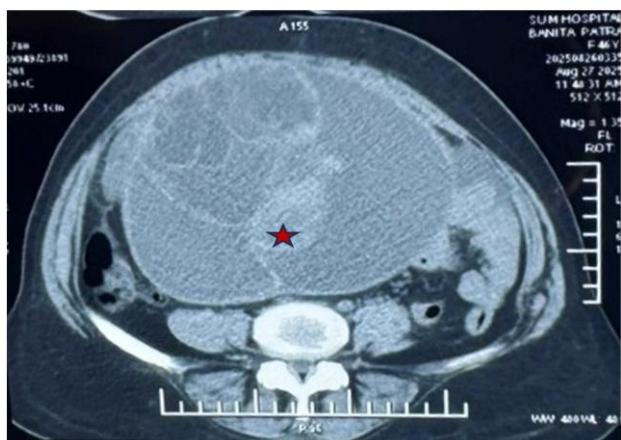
Contrast-enhanced CT showing multiloculated ovarian cyst with torsion features. Red star points towards solid areas.
